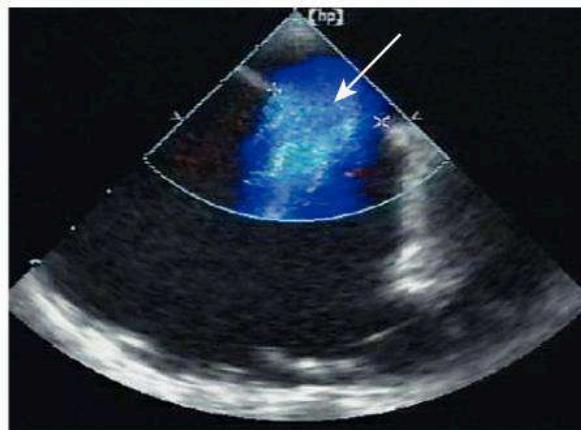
Transoesophageal echocardiogram of an atrial septal defect. The defect is clearly seen (arrow) between the left atrium above and right atrium below. Doppler colour-flow imaging shows flow (blue) across the defect.
